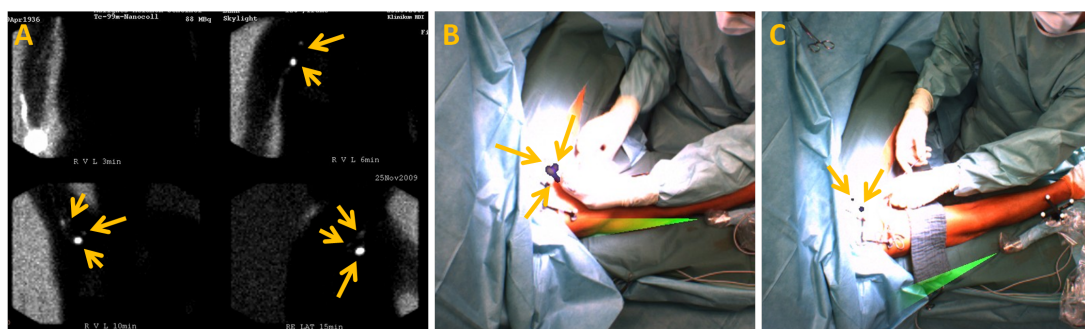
Example of results with in axilla. (A) shows the scintigraphy were 3 SLNs are visible in a triangular configuration. (B) shows the pre-incision image were the 3 SLNs are visible too. (C) is an acquisition after the resection of the first SLN.
